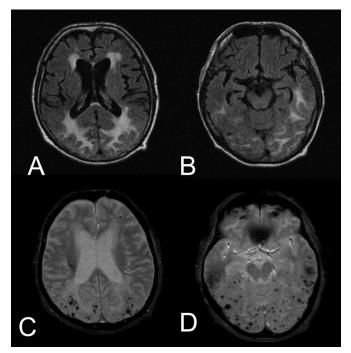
(A, B) Fluid-attenuated recovery images show vasogenic edema in occipital white matter. (C, D) T2*weighted MR images show multiple microhemorrhages in a posterior circulation distribution.
